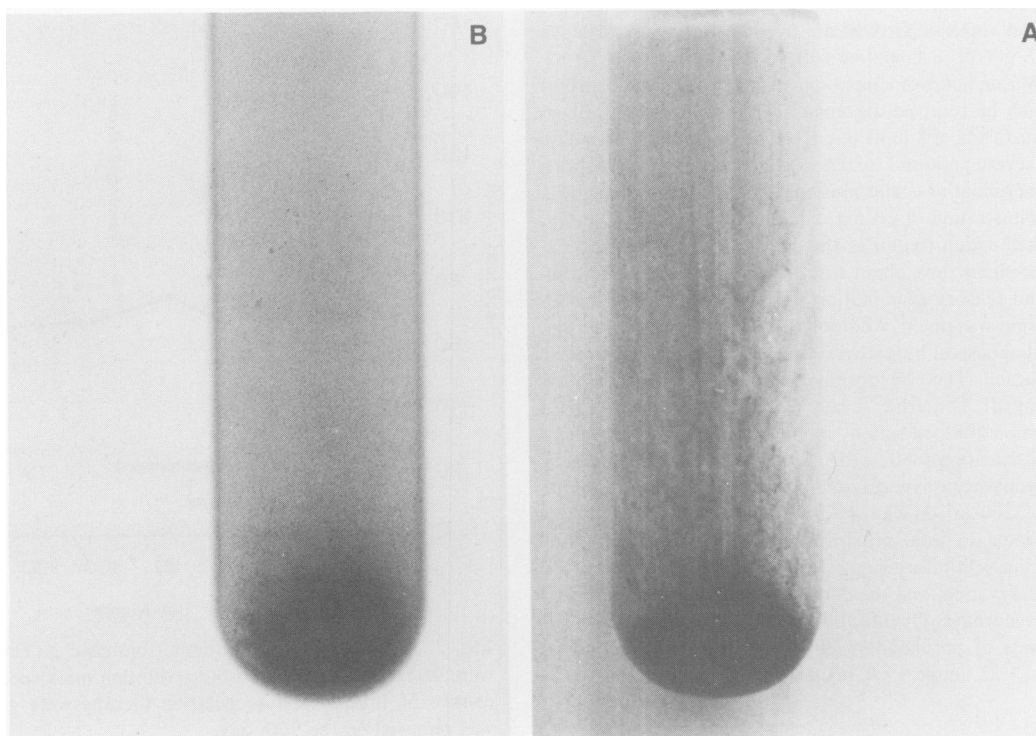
Pseudocyst fluid obtained from case 2 and centrifuged showing a large black pellet (3B). An X-ray of the tube shown in Fig. 3B was obtained and is printed as a positive in Fig. 3A.
